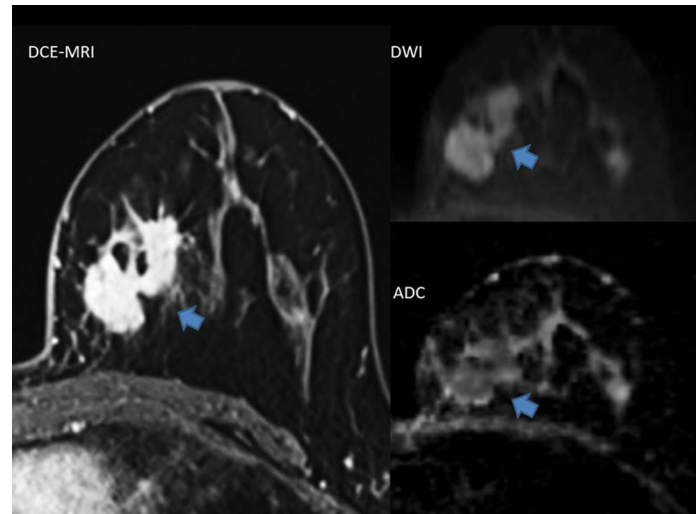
Breast carcinoma. A 52-year-old female patient with breast carcinoma. Dynamic contrast-enhanced (DCE) magnetic resonance image (MRI) shows an intensely enhanced spiculated mass. The lesion is hyperintense (bright) on diffusion-weighted imaging (DWI) and hypointense (dark) on the apparent diffusion coefficient (ADC) map. The lesion is restricting diffusion
